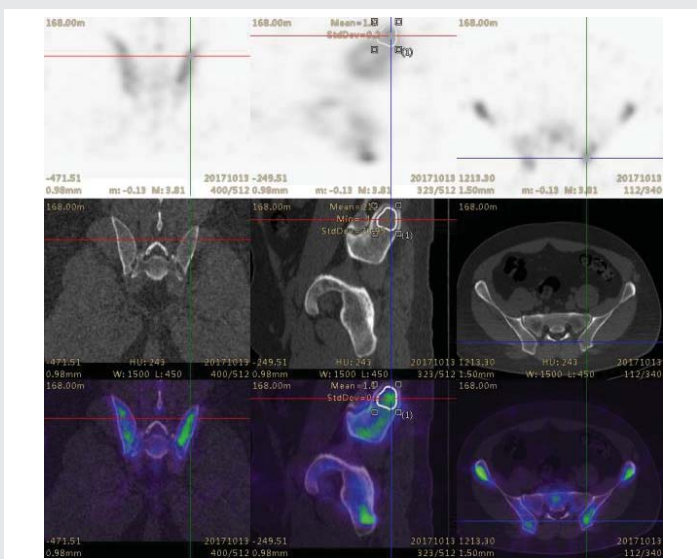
Transaxial, saggital and coronal images of a patient's SPECT/CT fused data of pelvis.
